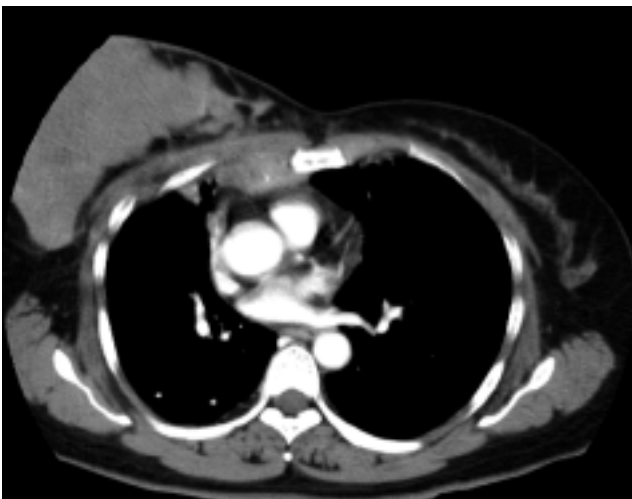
Computed tomography showing a breast mass.
